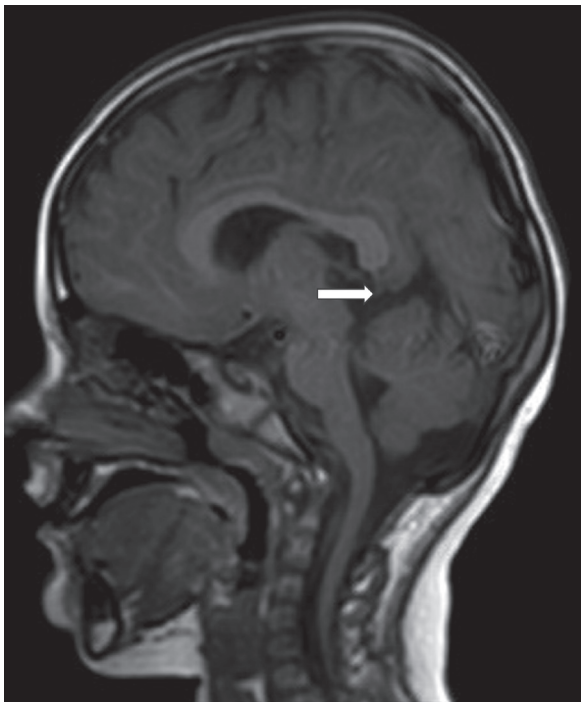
In the sagittal T1-weighted MR image of the same patient as Figure 1, the herniated cuneate gyrus extends towards the superior cerebellar cistern (white arrow)
